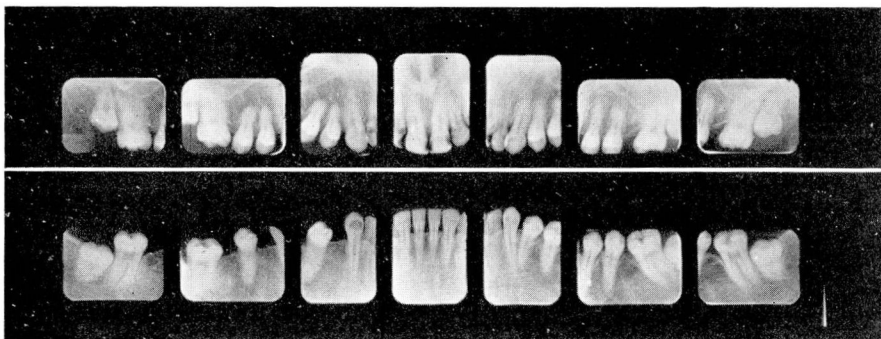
Roentgenogram of teeth of patient.
